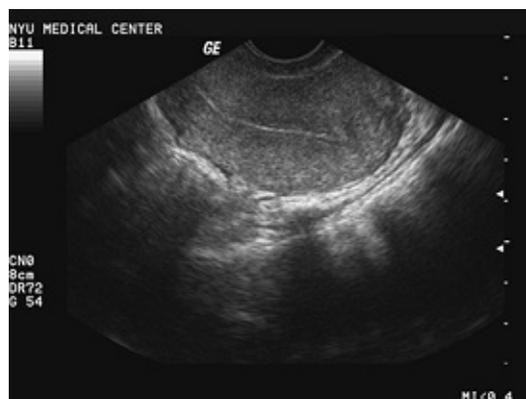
Long axis transvaginal ultrasound image of a postmenopausal patient with a history of uterine bleeding. A thin, linear, distinct endometrial echo here has a negative predictive value of 99%. Notice how it is clearly seen taking off from the endocervical canal.
